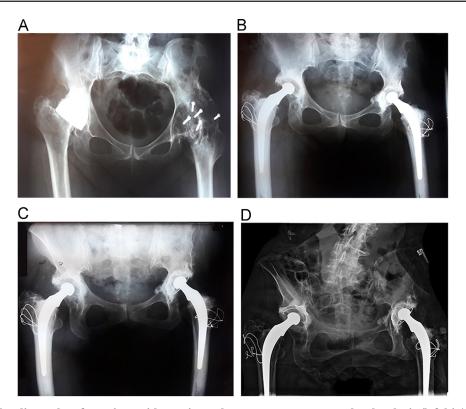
Figure – Sequential radiographs of a patient with previous Thompson osteotomy and arthrodesis (left hip), and vitallium cup (right hip) secondary to developmental dysplasia of the hip bilaterally and pyogenic arthritis in the left hip. (A) 1971. Previous to THA's. (B) 1973. After sequential THA's. (C) 1992. 20-years follow up. (D) 2008. 38-years follow up.
